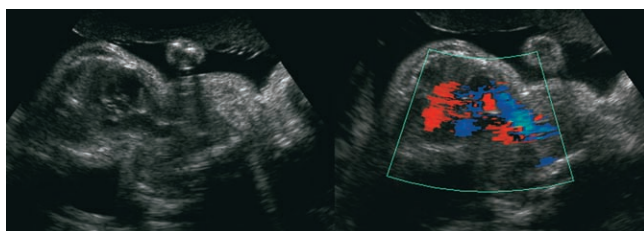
Thoracopagus twins showing shared great vessels using gray-scale and color Doppler imaging.
